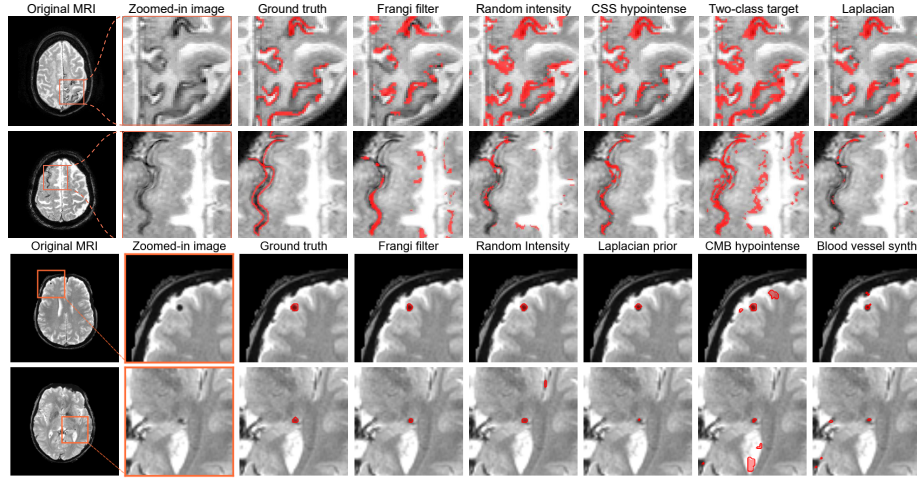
Visual comparison of segmentation performance. Columns show, from left to right, the original MRI scan, zoomed-in view, manual ground-truth annotation, Frangi filter output, and outputs from the four ablation configurations: random intensity sampling, Laplacian prior, cSS/CMB hypointensity constraint, and lesion-specific refinement. The lesion-specific refinement corresponds to a two-class target for cSS and blood-vessel synthesis for CMBs.
